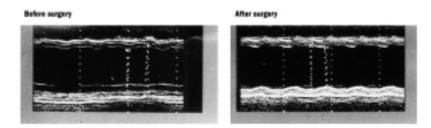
Echocardiographic study, before (left) and after myoblast transplantation (right), shows improvement of segmental contractility in the posterior wall. From Menasche et al.²⁴, modified.
